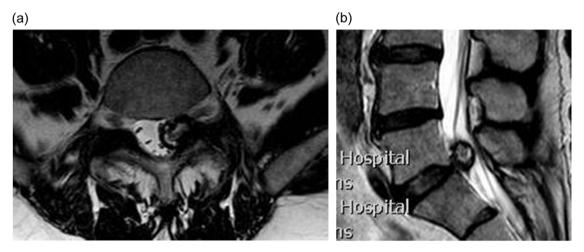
(a) Axial T2 weighted MRI showing a left sided L5/S1 synovial cyst impinging on the left S1 nerve root; (b) sagittal T2 weighted MRI showing a L5/S1 synovial cyst.
